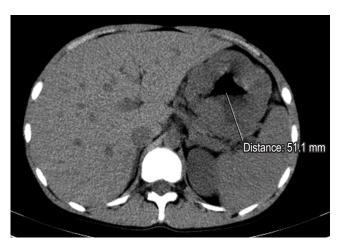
Image of patient's CT scan.
